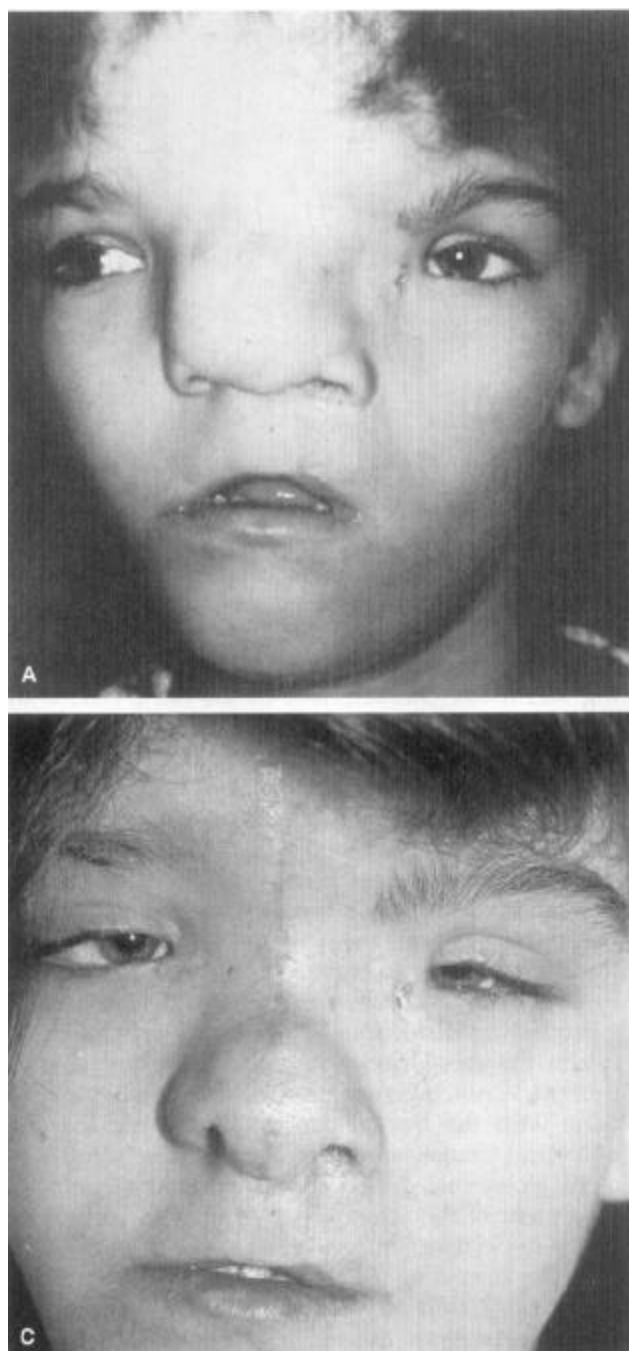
(A) Preoperative photograph of the girl with 2-12 cleft. The cleft of the lip had been previously repaired. (B) Three-dimensional computed tomography scan examination reveals the bony route of the no. 2-12 cleft. (C) Postoperative 6-month view of Case 1.
